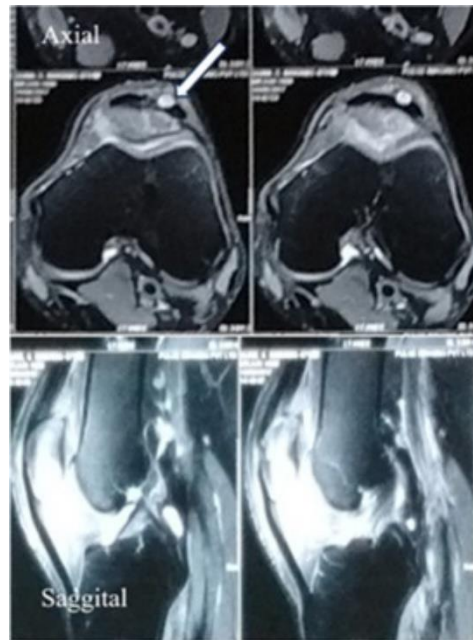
MRI images (A) Axial Section; (B) Sagittal Section
